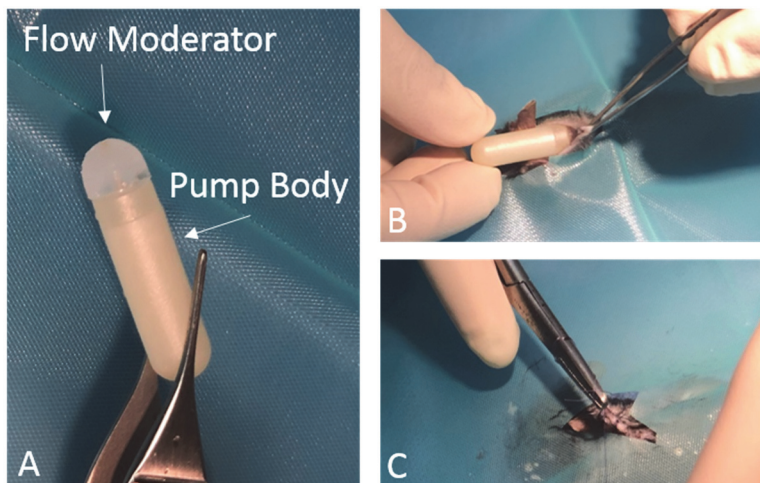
MRI compatible osmotic minipump implantation. After preparation of a subcutaneous tunnel in the dorsal neck region, the osmotic minipump is inserted gently through the skin incision (B). After pump insertion, the skin incision is sutured (C).
